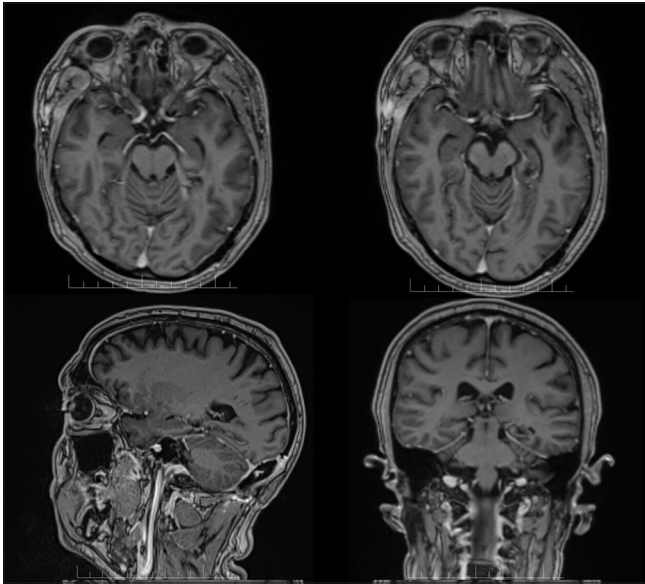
Postoperative magnetic resonance imaging T1 weighted with contrast. Surgical cavity in the posterior third of the left temporomesial region with complete resection of the cavernoma.
